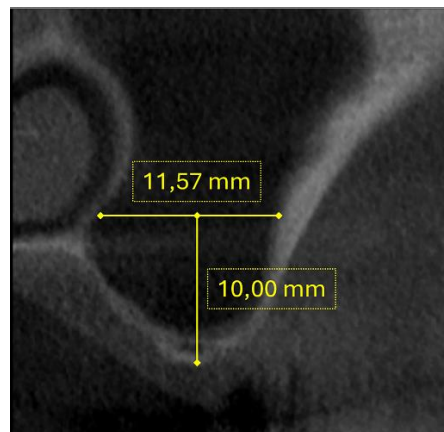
CBCT cross-section confirming the extremely limited residual crestal height and the presence of a narrow maxillary sinus.
